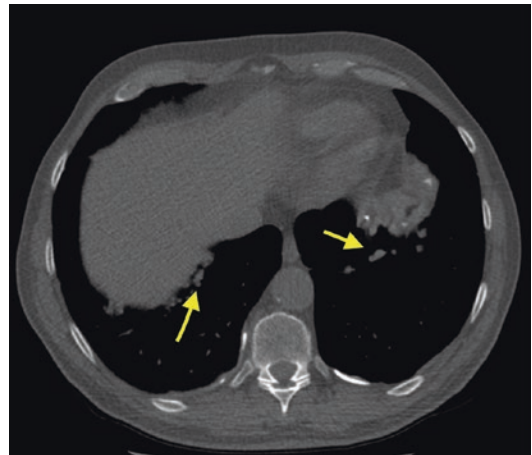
Same patient, unenhanced high-resolution CT showing multiple nodular thickening of the diaphragmatic pleura (yellow arrow). Malignant mesothelioma is an uncommon and fatal neoplasm of the serosal lining of the pleural cavity, peritoneum, or both. The risk amount of mesothelioma in asbestos-exposed population is approximately 10% over their lifetime [21]. HRCT appearance is of a soft-tissue attenuation nodular mass which extends along pleural surfaces including into pleural fissures and often creating a pleural rind [22]. In 20% of cases calcifications are seen and usually represent engulfed calcified pleural plaques rather than true tumor calcification. It is possible to identify chest wall invasion through the identification of infiltration or direct extension in bone or muscle. Moreover advanced tumor invasion of the pericardium, diaphragm, and abdomen is a common finding
